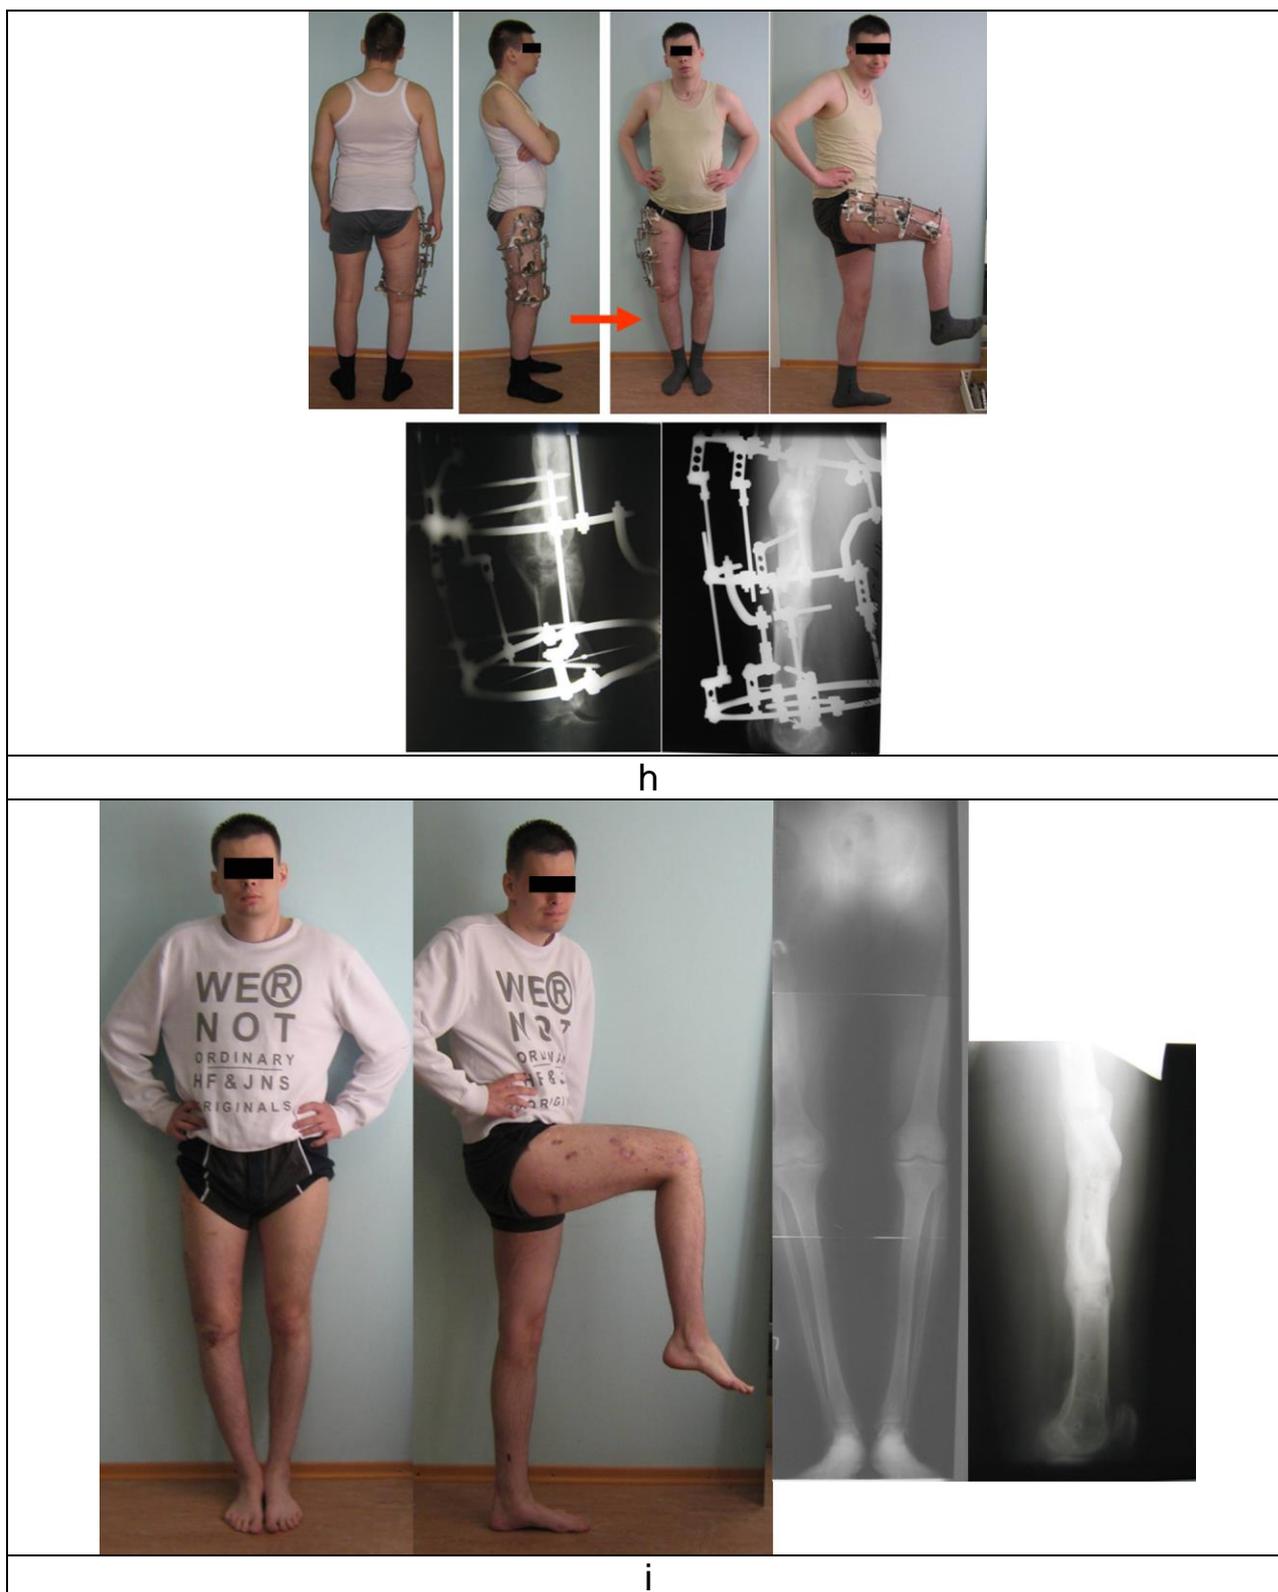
Photographs and roentgenograms of patient E. Before, during and after treatment
